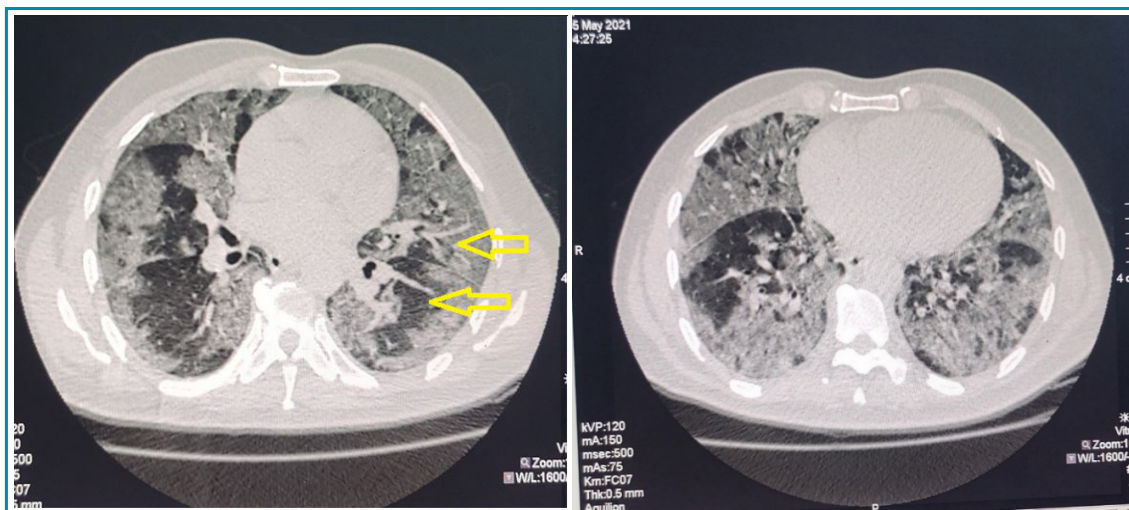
HRCT axial view showing bilateral multilobar ground glass opacities with interlobular septa thickening and dilated vessels / vascular sign (arrows) (Severity score: Moderate- involving 50 – 75% of bilateral lower lobes)
